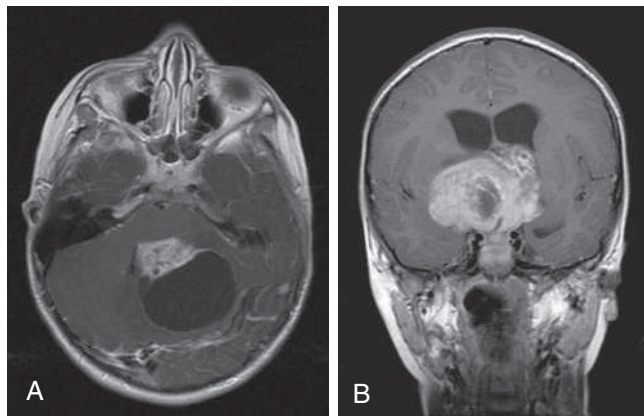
A, Gadolinium-enhanced axial T1-weighted MR image in a 4-yr-old child with cerebellar pilocytic astrocytoma presenting with headaches, emesis, and ataxia demonstrates a predominantly cystic mass with enhancement of the solid component and enhancement of the capsule. B, Gadolinium-enhanced coronal view of a cystic juvenile pilocytic astrocytoma of the suprasellar region from a 4-yr-old child presenting with visual loss and headaches.
